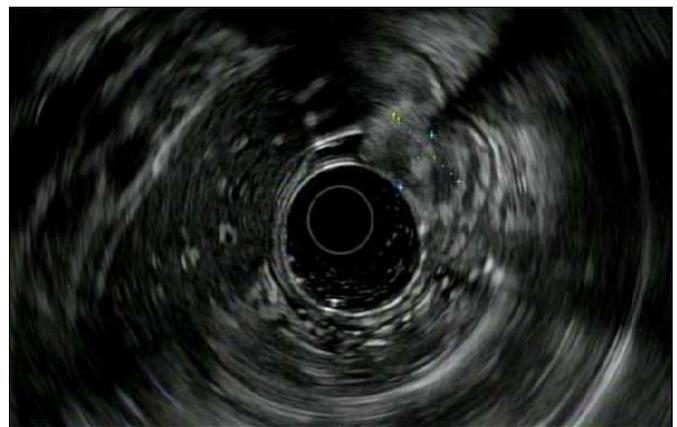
Endoscopic ultrasound of the sessile polyps in the gastric body.
